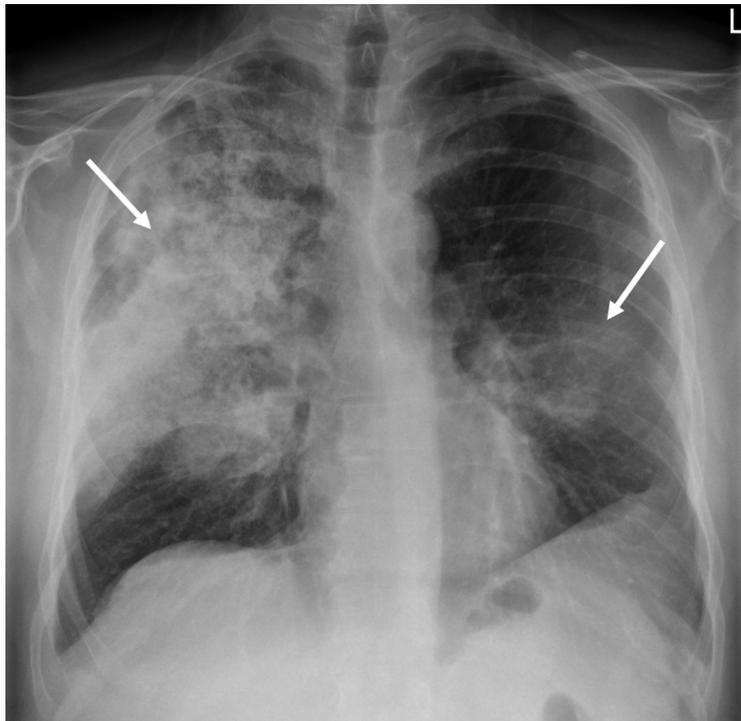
Bilateral pneumonia on chest X-ray (right upper lobe and left lower lobe consolidations).
